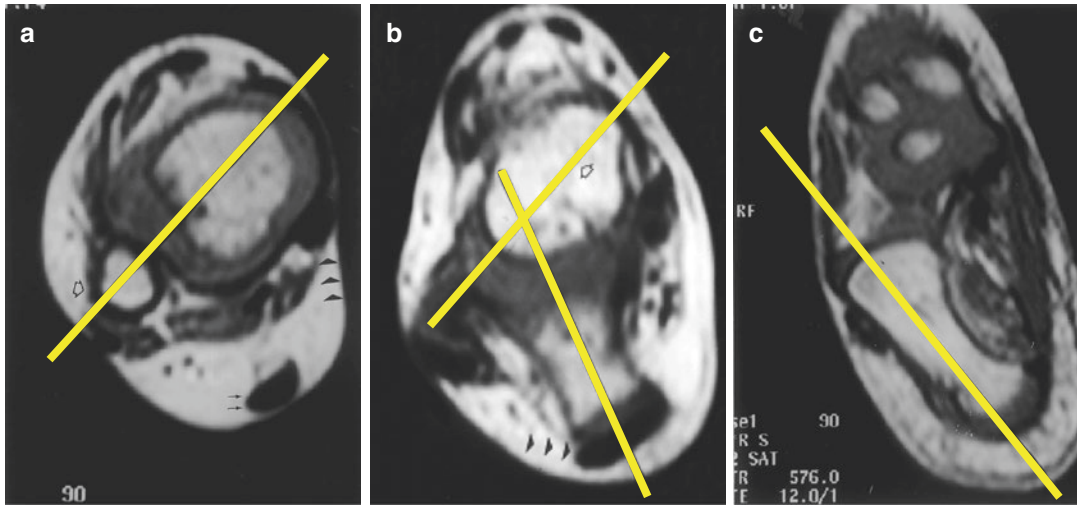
AP MRI talo-calcaneal angle from Pekindil (2001)
